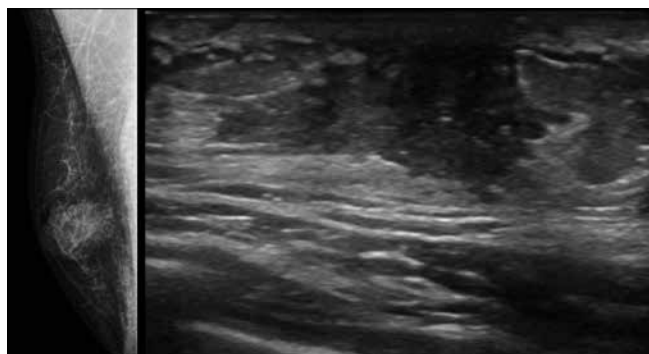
Patient having nodular gynecomastia on mammography had dendritic gynecomastia at ultrasonography
